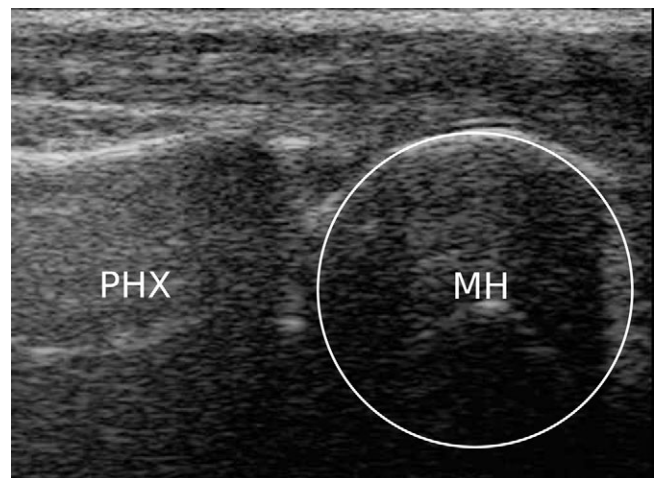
The ultrasound probe placed longitudinally on the plantar side of the first metatarsophalangeal joint (MTPJ) shows the round profile of the metatarsal head (MH; right) and the inferior border of the proximal phalanx (PHX; left). The curvature of the MH can be approximated by a circle (in white).
